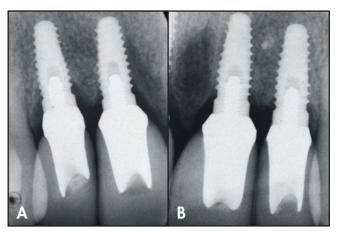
Teeth #7 and #8 at 2 years postoperatively. 15B. Two-year follow-up radiograph shows stable bone levels around implant at sites #9 and #10.
